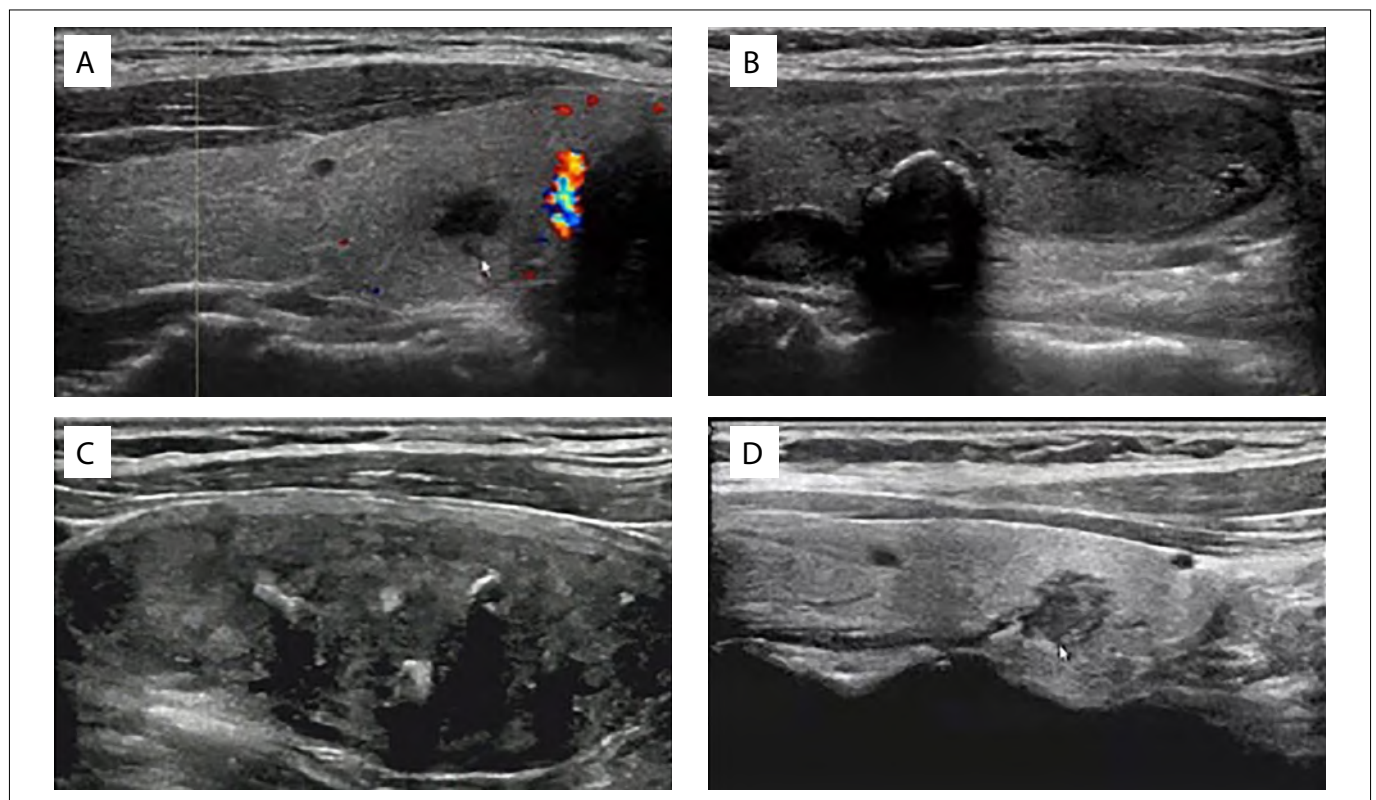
Characteristic ultrasonographic changes of primary thyroid tuberculosis. Ultrasound indicated that the thyroid mass had unclear boundaries and no obvious blood flow signal inside the mass (A); or was surrounded by a strong echo (B); or by a mostly mixed echo (C); or by a scattered strong echo in some parts (D).
